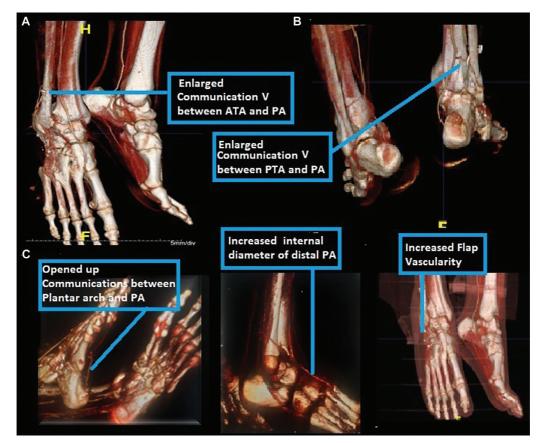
Postoperative findings in computed tomography angiography. Findings of the flap limb versus normal limb. RPA, reverse peroneal artery.
